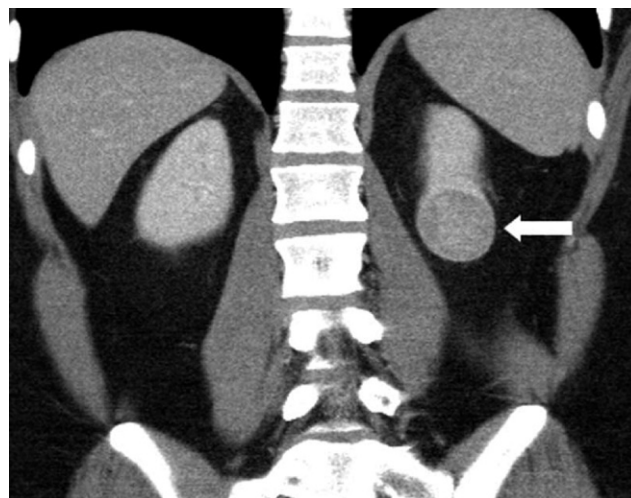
Sporadic chromophobe RCC. Coronal, multiplanar reformatted image from a contrast-enhanced CT shows a well-circumscribed solid mass with homogenous enhancement in the left lower renal pole.
